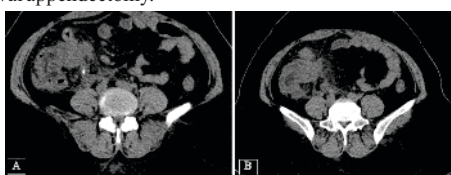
Non contrast CT abdomen (A) shows ill-defined collection with fat stranding in the right iliac fossa with an appendicolith; (B) caudally shows the confined collection and fat stranding.
